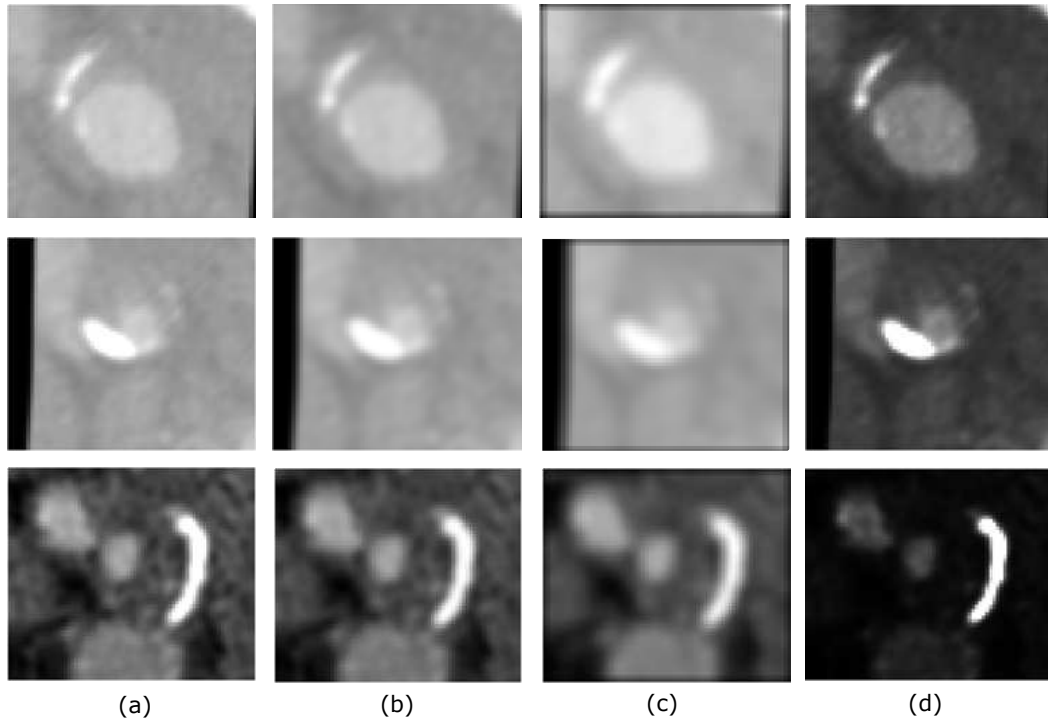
Examples of images resulting from the Gaussian, mean, and Sigmoid filters: a) Original CTA images; b) Images resulting from the original images after applying a Gaussian filter with $\sigma = 2$, c) a mean filter with $N = 3$, and d) a Sigmoid filter with $\alpha = 50$ and $\beta = 256$.
